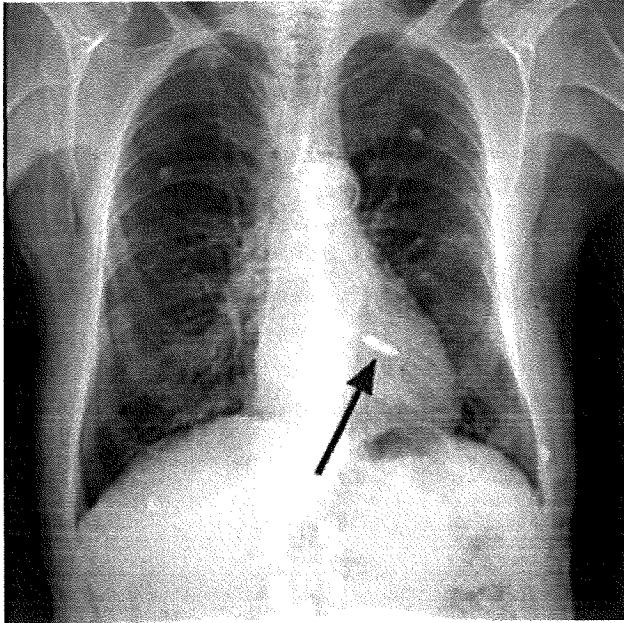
Chest radiograph (posteroanterior view) showing a leadless pacemaker in the region of the right ventricle, which could be verified to be retrosternal on a lateral film. Prior sternotomy and significant ascending aortic calcification are also noted.
